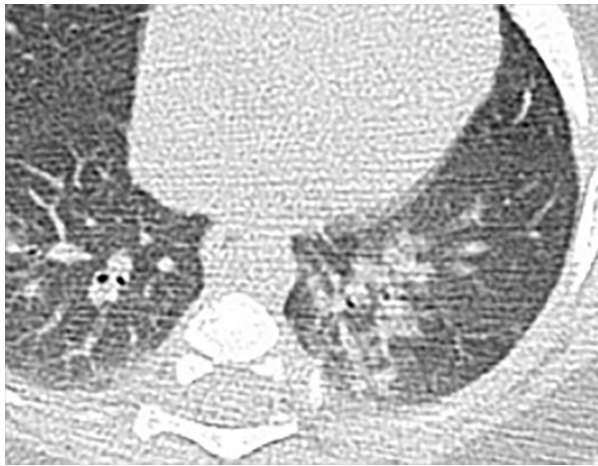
Chest CT findings of pediatric patients with COVID-19 on transaxial images. (a) Male, 2 months old, 2 days after symptom onset. Patchy ground-glass opacities GGO in the right lower lobe; (b) Female, 4 years old, 4 days after symptom onset, two subpleural nodules in the right lower lobe; (c) Male, 8 months old, 6 days after symptom onset. Bronchial wall thickening and peribronchial ground-glass opacities and consolidation are noted in the left lower lobe.
